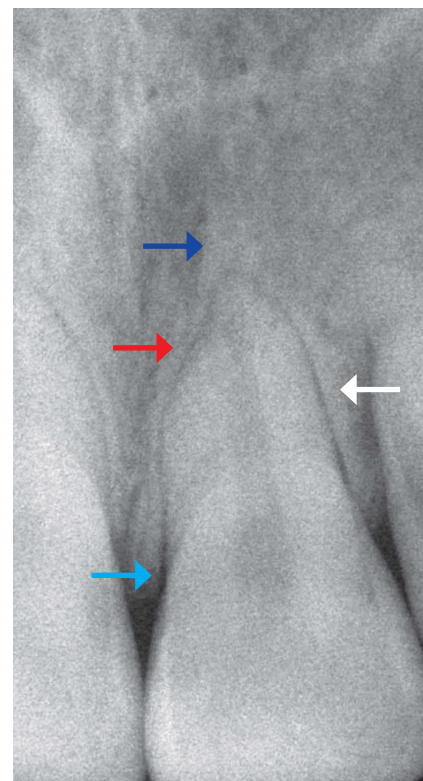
Apical inflammatory radicular resorption associated to occlusal trauma, lamina dura thickening (white arrow), broadening of the periodontal space (red arrow), with periapical periodontal bone density increase (dark blue arrow) and V-shaped vertical bone loss (light blue arrow). This phase with inflammatory apical resorption occurs after a long period of overloading.
